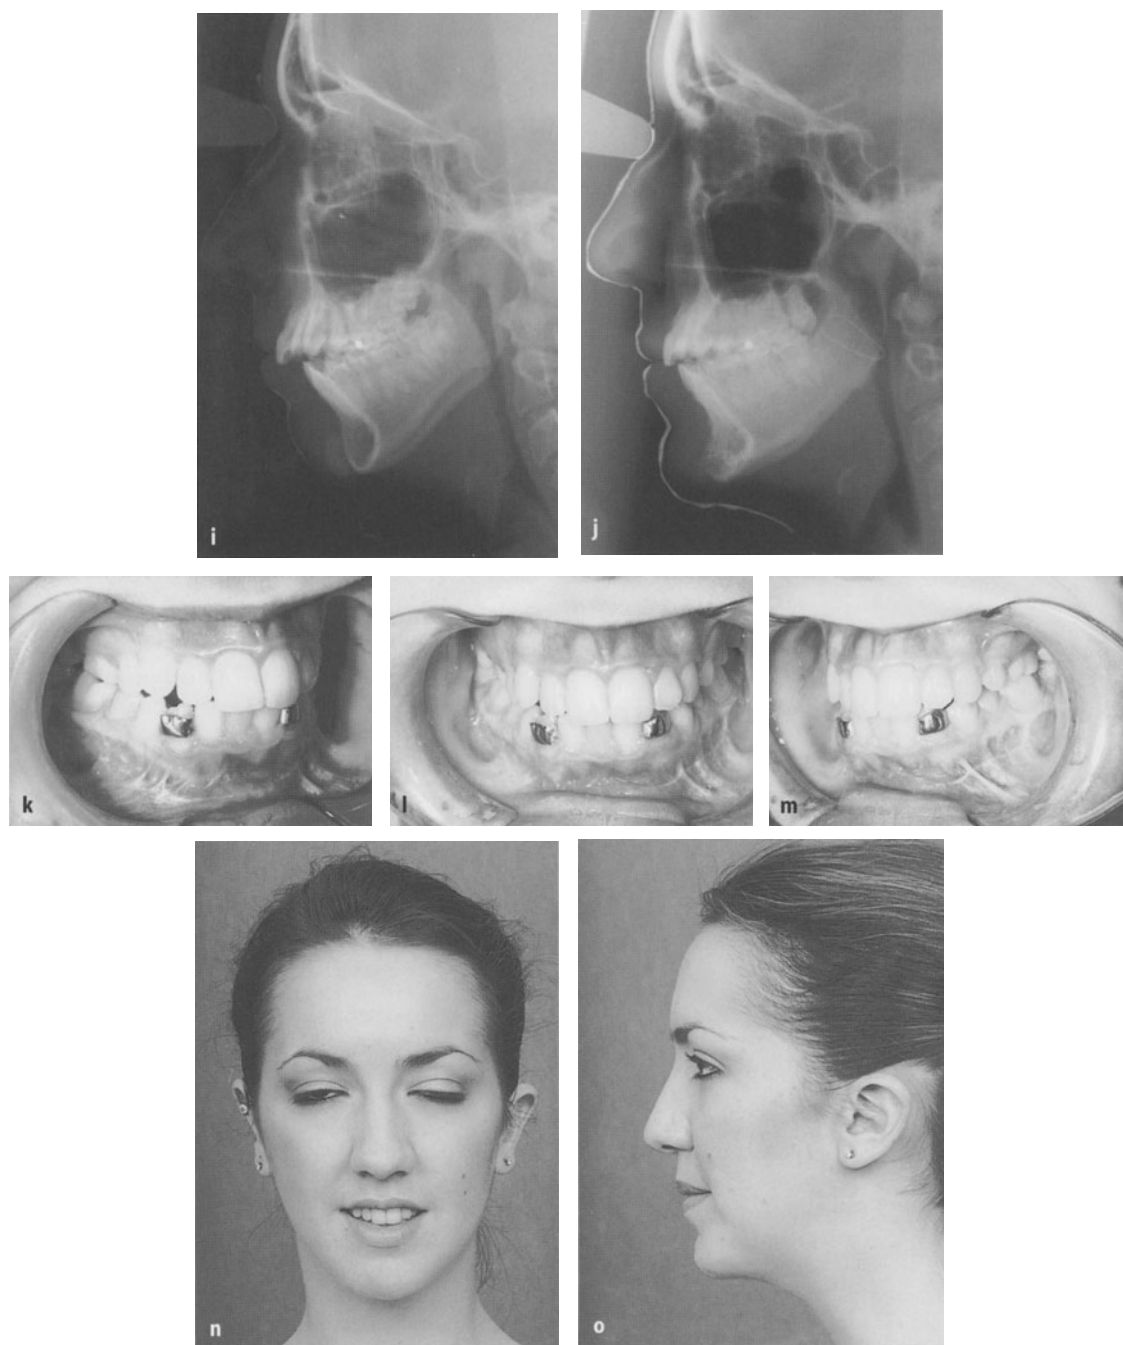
Case of bilateral asymmetrical condylar hypoactivity due to juvenile arthritis. Patient's presurgical a front and b profile views showing slight asymmetry of the chin to the left and marked retromandibulism. c–e The presurgical occlusion pictures show a circular open bite and the situation after earlier extraction of teeth 14, 24 and 31 with a class II relationship. f The panoramic radiograph shows the consequences of earlier condylar hypoactivity, mainly on the left side. g, h The TMJ tomograms disclose that both condyles have been affected by arthritis, some time in childhood, the right less severe than the left. i The presurgical lateral cephalogram shows clearly the shortness of the mandible and its retroposition with an open bite. The configuration of the chin is normal, but it is short in height (depth). In front of it the silastic chin implant is recognizable. k–m Patient's occlusion 6 months after surgical correction. n Front and o profile appearances. j The lateral cephalogram taken at the same time discloses the elongation of the horizontal rami achieved and some calcification of the lyo-cartilage chin onlay. It also discloses the tendency to a slight open bite relapse
